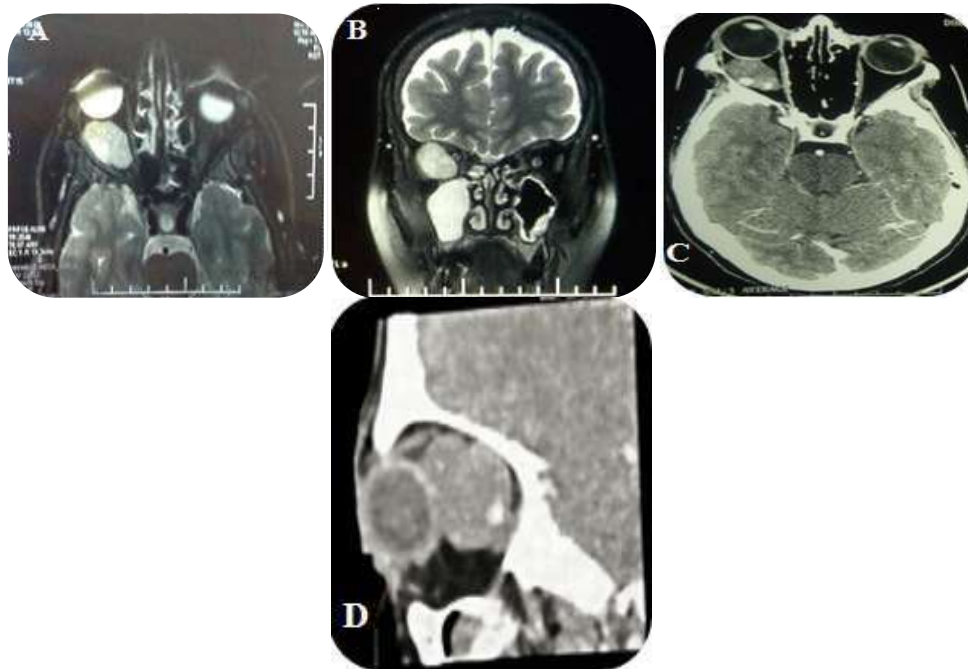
Cerebral MRI A, B in axial and coronal section in T2 shows a hemangioma intraconical cavernous in well-limited homogeneous T2 hypersignal. Brain CT. C, D, in sagittal and coronal axial section shows a dense process from the outset
